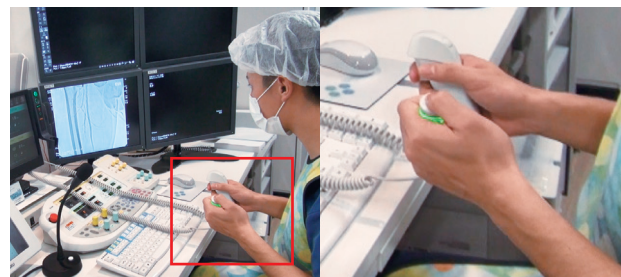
Start acquisition of the lower extremities when the radiological technologist gives the signal. Long-view images of the overall lower extremities are acquired by using the X-ray emission switch (left hand) and the ChaseConsole dedicated table controller (right hand) to control table movement to follow the flow of contrast media.
